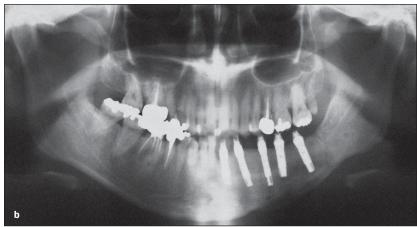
(a) Dental CT obtained before the series of operations and (b) 1 obtained 4 months after the second vertical distraction osteogenesis. Direct measurement of the height on the 2 radiographs revealed that mandibular height was lengthened 20 mm vertically by this series of surgical treatments. The CT image obtained after the second distraction osteogenesis revealed 4 layers in the mandible and also showed the different densities of the 2 areas of distracted bone. The lower part of the distracted gap was mature at 10 months after distraction; the upper bone was mature at 4 months after distraction. In the lower layer high radiopacity was observed in bone marrow and the thickened lateral cortex, but in the upper layer the opacities were less. In the upper layer, the elongated dimension at the lingual side was shorter than that at the buccal side, highlighting the deviation of the distraction device and augmented alveolar ridge to the lingual side.
